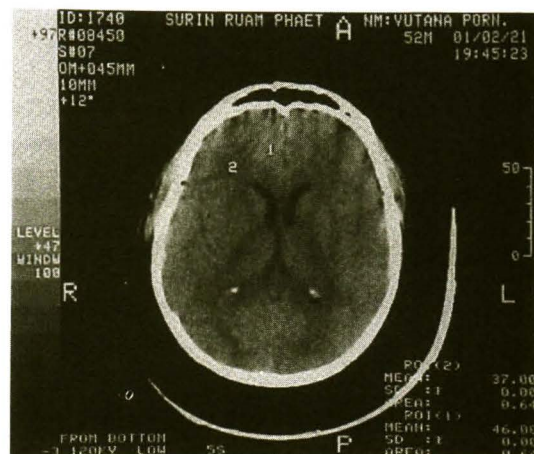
CT scan of the brain on day 6 after vaccination showing diffuse brain edema without mid line shift.
